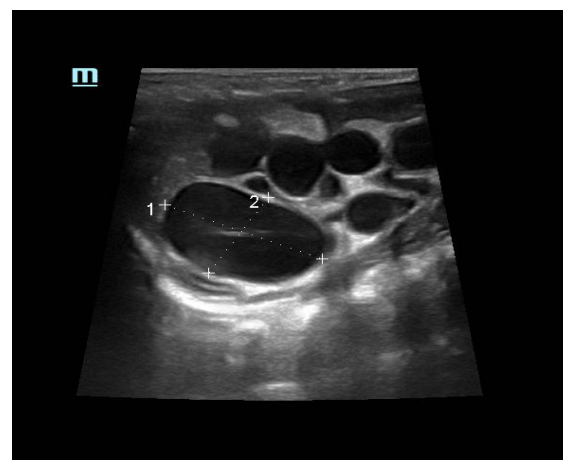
Ultrasonography of the right kidney showing an enlarged kidney (5.39×3.39 cm) almost completely replaced by multiple non-communicating cysts of varying sizes with near-complete absence of normal renal parenchyma, consistent with multicystic dysplastic kidney
